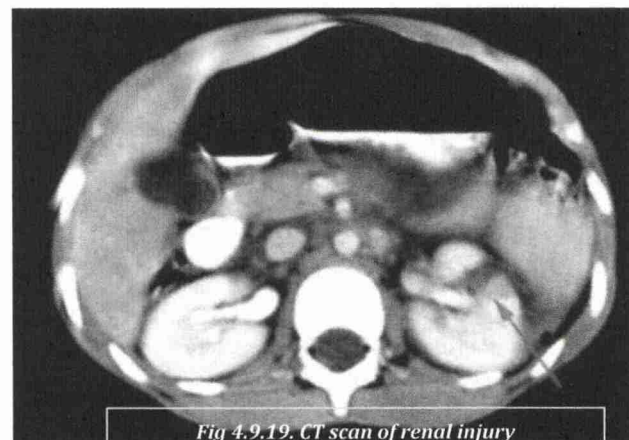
CT scan of renal injury
